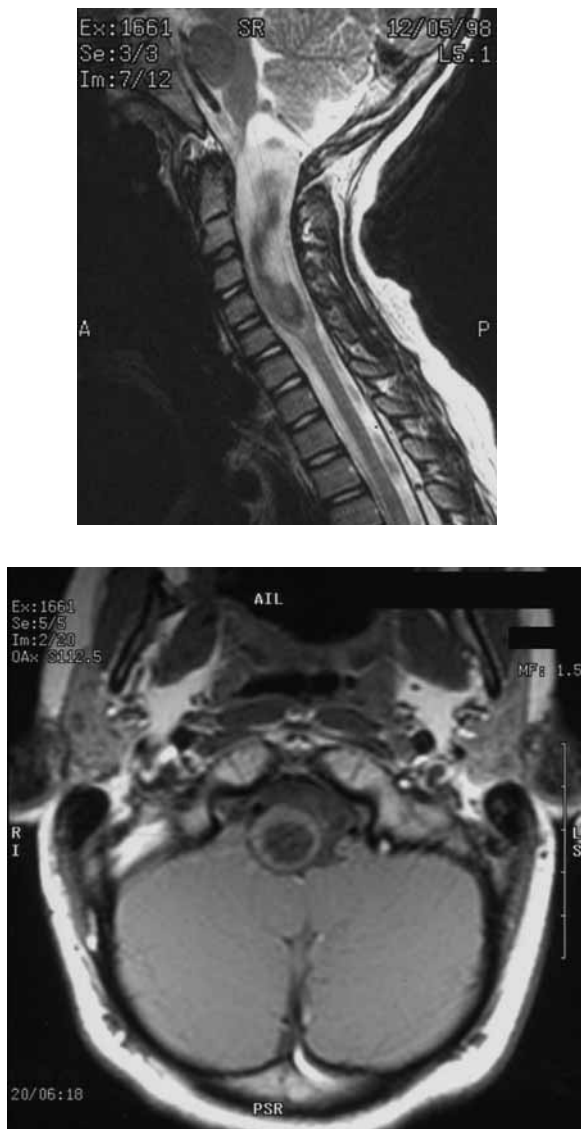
Case 1 at diagnosis*: Sagittal and coronal MRI scans indicating a lower brainstem/upper cervical cord low-grade astrocytoma. Report indicated a large intramedullary tumour mass expanding the cervical cord and extending from the level of C5/6 disc inferiorly to the caudal medulla.
